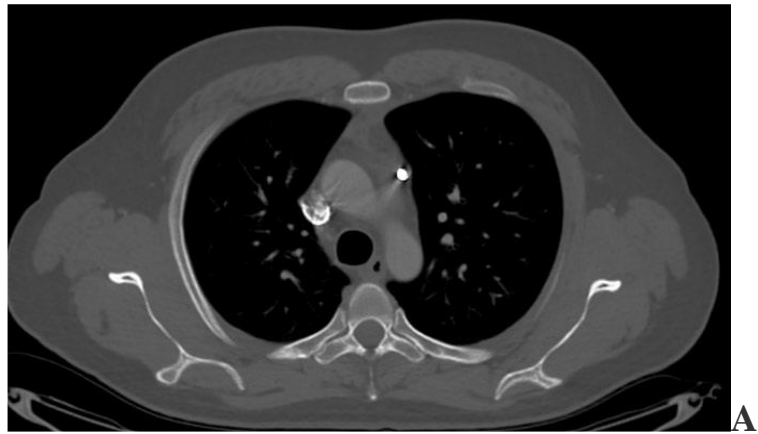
Spiral CT aortography: a metal fragment located near the pulmonary trunk, no signs of extravasation were found. A – axial plane; B – coronary plane; B – sagittal plane.
